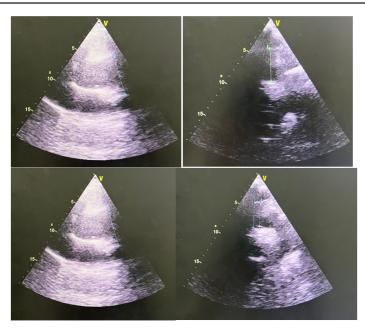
transthoracic echocardiography images showing an aneurysm of the ascending aorta after the sinotubular junction sparing the first portions of the ascending aorta.
